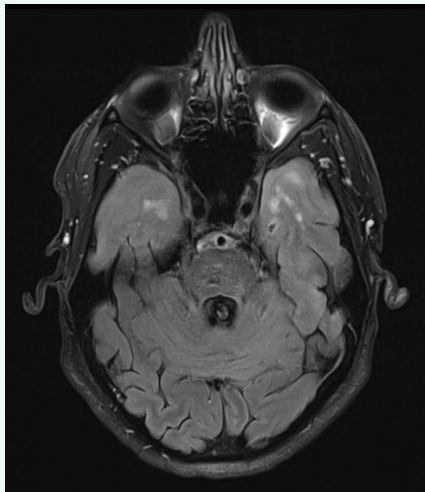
Axial T2/FLAIR MRI demonstrating anterior temporal lobe white matter involvement.
